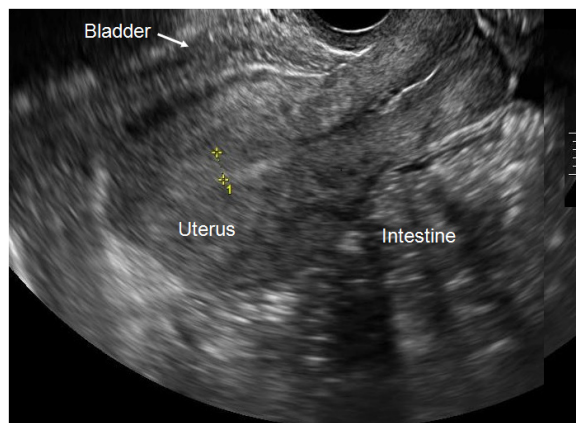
Sonogram findings at follow-up 18 months after surgery.
